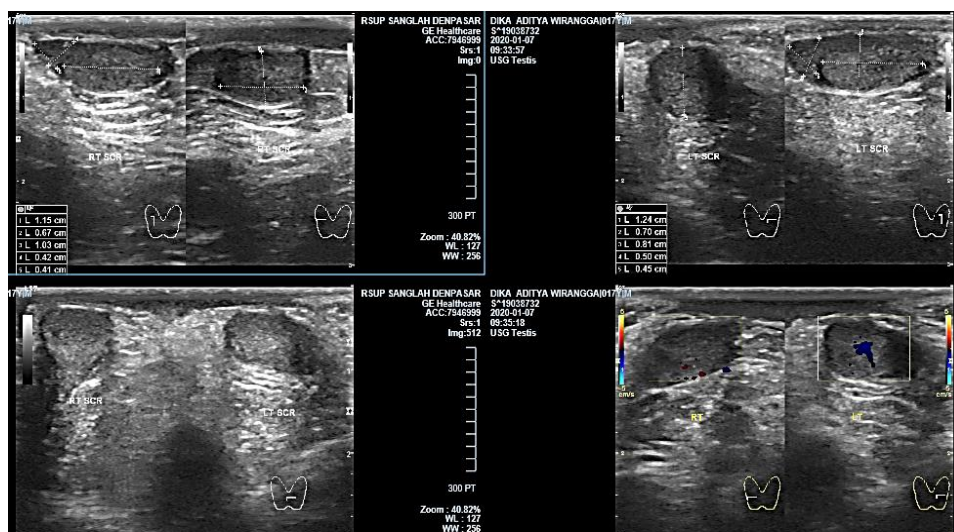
Ultrasonography result of patient's testicles
